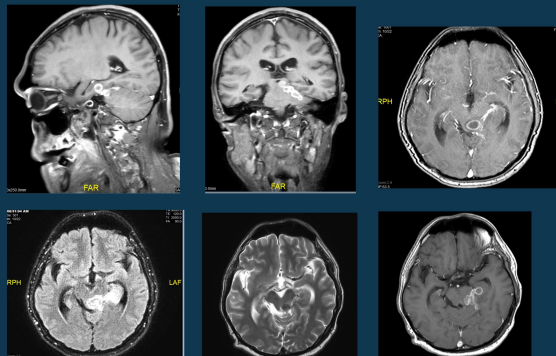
The MRI showed multiple rim-enhancing lesions in the left brainstem, left cerebellum, left ambient cistern, left temporal subcortex, and mild ventricular dilation. These findings suggest tuberculous meningitis and tuberculoma.
